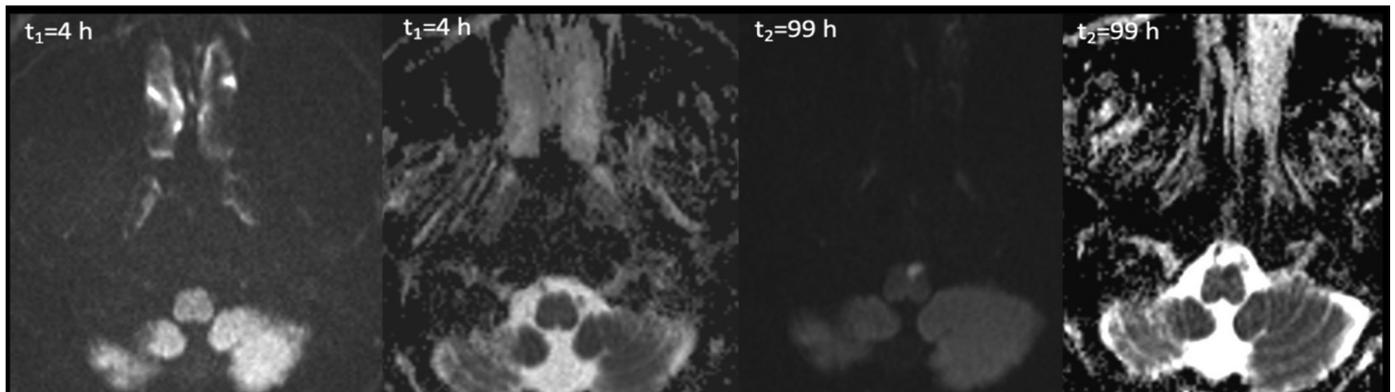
Brainstem mini-stroke: A 61-year-old man with hypertension and dyslipidemia was admitted with acute onset right-sided hemihypoesthesia, dysphagia and mild ataxia (admission NIHSS: 12; 24th-hour NIHSS: 10). While the lesion is not detected in the DWI and apparent diffusion coefficient (ADC) mapping performed at the fourth hour following the onset of the symptom, a DWI bright-ADC dark acute medullary infarction in the left medullary pyramid is clearly discerned in the control imaging taken at the ninety-ninth hour
